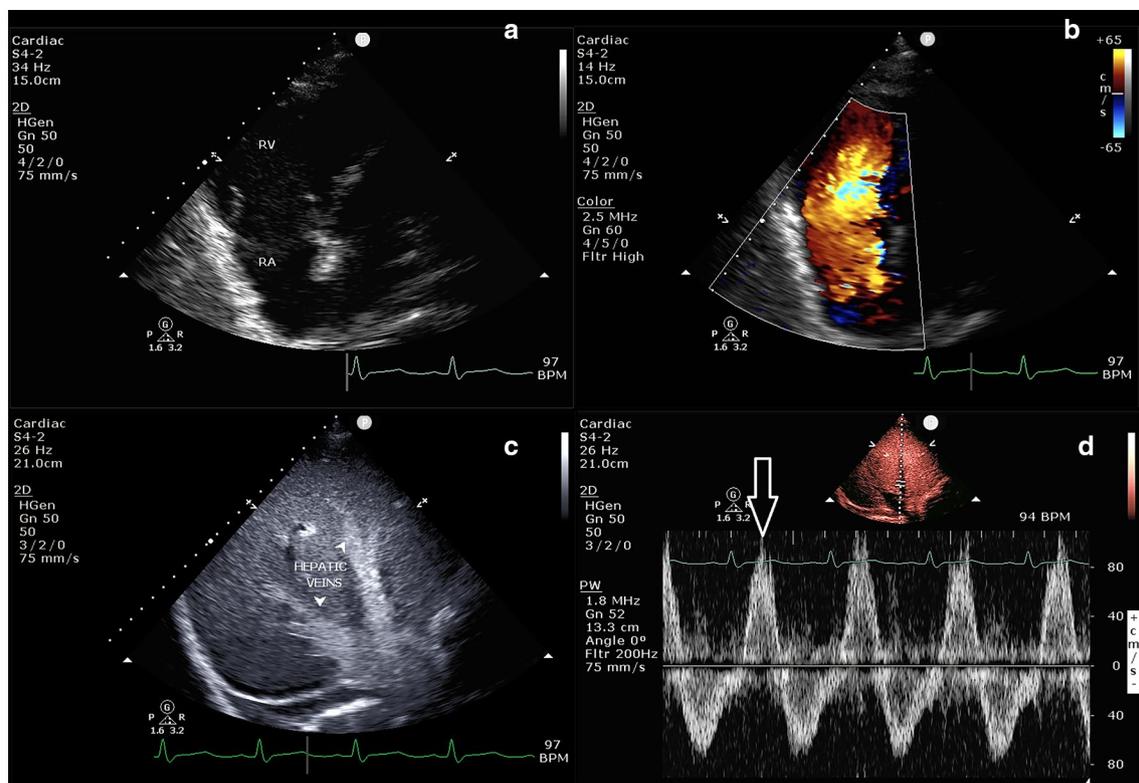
a B-mode ultrasonography depicts the tricuspid valve of the patient after partial excision of anterior and posterior leaflets; RV right ventricle, RA right atrium. b Colour Doppler examination shows massive tricuspid valve regurgitation. A large volume of blood regurgitates back into the right atrium during systole (end-systolic depiction). c Infusion of agitated saline reveals systolic reverse blood flow in the hepatic veins due to right atrial volume overload. d Pulse wave (PW) Doppler examination of the hepatic veins shows systolic reverse flow (arrow)
